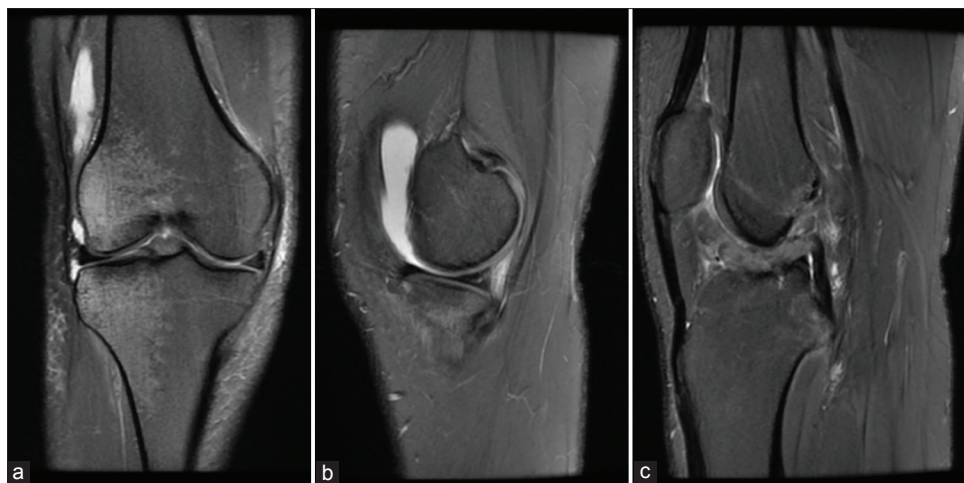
Coronal and sagittal PDFS MR images of knee joint showing (a) clip injury pattern of edema involving lateral femoral condyle and lateral tibial plateau. Grade I sprain of MCL is also seen. (b,c) Grade II tear in posterior horn of medial meniscus and ACL tear in same patient, together forming O'Donoghue's triad. Mild joint effusion is also present.
